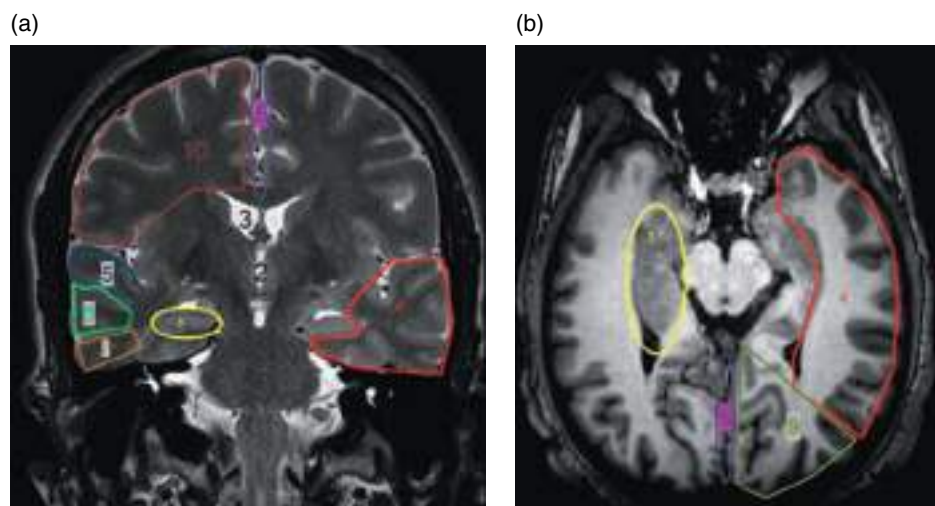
Lobar and cortical anatomy. (a) Coronal T2-weighted MRI. (b) Axial T1-3D-weighted MRI (plane at the level of the hippocampus). 1, hippocampus; 2, third ventricle; 3, body of the lateral ventricle; 4, temporal lobe; 5, superior temporal gyrus; 6, middle temporal gyrus; 7, inferior temporal gyrus; 8, interhemispheric fissure; 9, occipital lobe; 10, frontal lobe.
